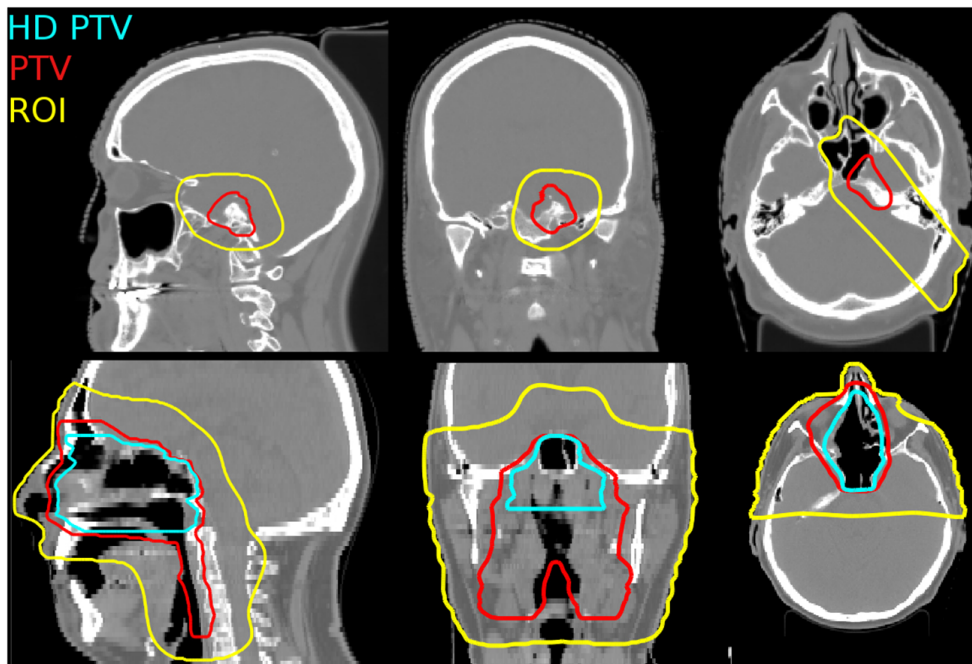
(top row) Axial, coronal and sagittal slices of the CT image of Pat1, including the FMpCT ROI and PTV. (bottom row) The same for Pat2, with an additional high dose PTV (HD PTV).
